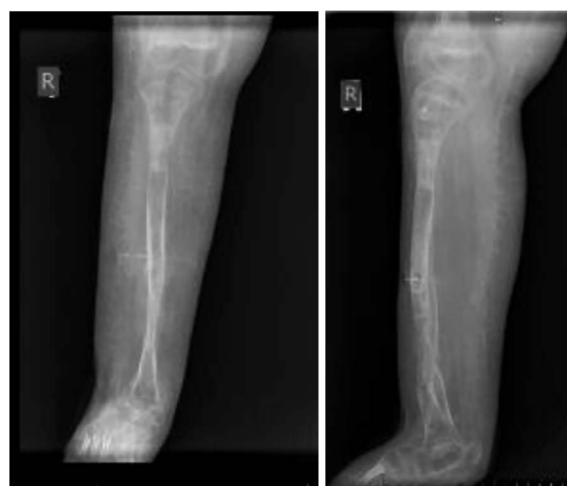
Radiographs of the right tibia in anteroposterior and lateral views after Ilizarov apparatus removal.
